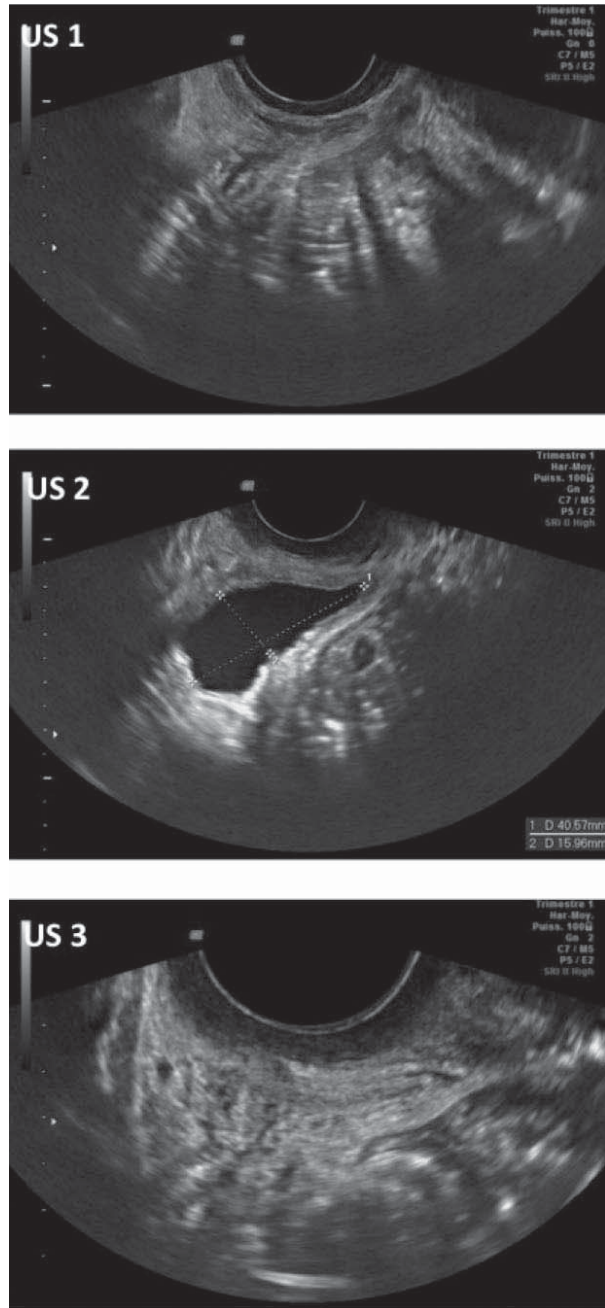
Ultrasound scan of the pelvis showing the different bladder filling status during the study demonstrate urinary origin of squirting
